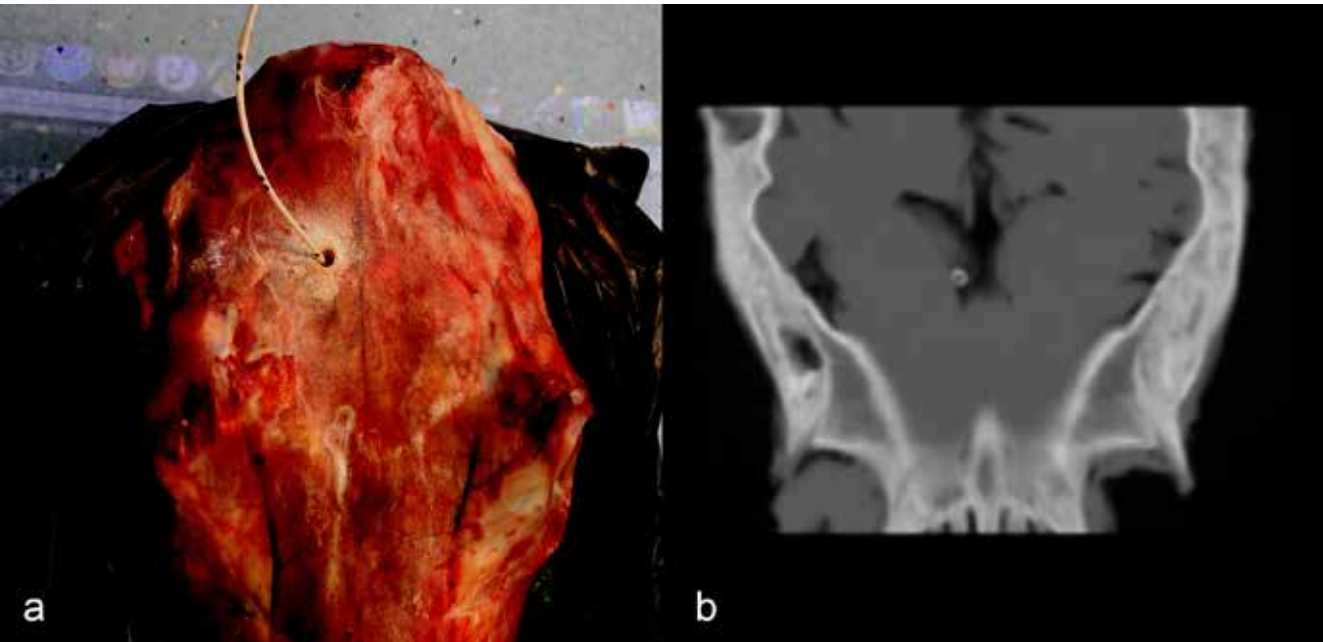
a) This figure shows the subject for the experimental procedure. In this figure the axial CT image of the brain was projected over the skull surface. b) Axial CT section image of the brain along the catheter shows the correct location of the needle.
